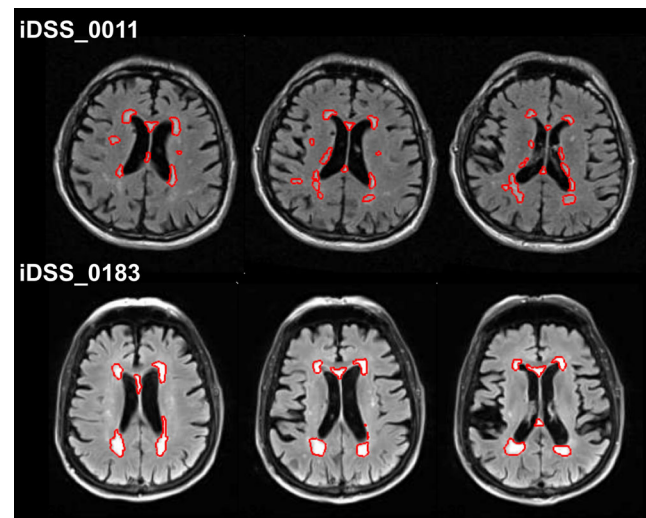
Two iDSS subjects with similar total WMH volume (iDSS_0011: 18.3 ml and iDSS_0183: 18.6 ml), but different confluency sum score (COSU) of the WMHs (21.9 and 8.8, respectively). The performance in the trail making test A was more strongly impaired in the subject with the larger COSU (z-score -2.4 and -1.0 , respectively). The red contour represents the automatically segmented white matter hyperintensities overlaid to the individual FLAIR image in native space. Three consecutive slices at the level of the inner ventricles are displayed for each subject
